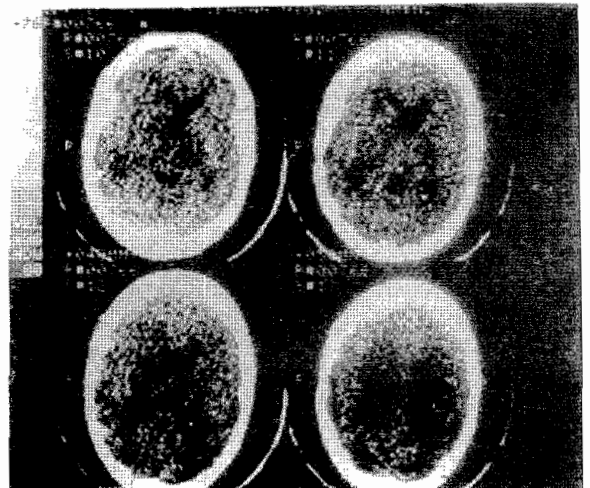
Non enhanced cranial CT scan for patient 2 showing loss of gray/white matter differentiation with effacement of the right lateral ventricle.
